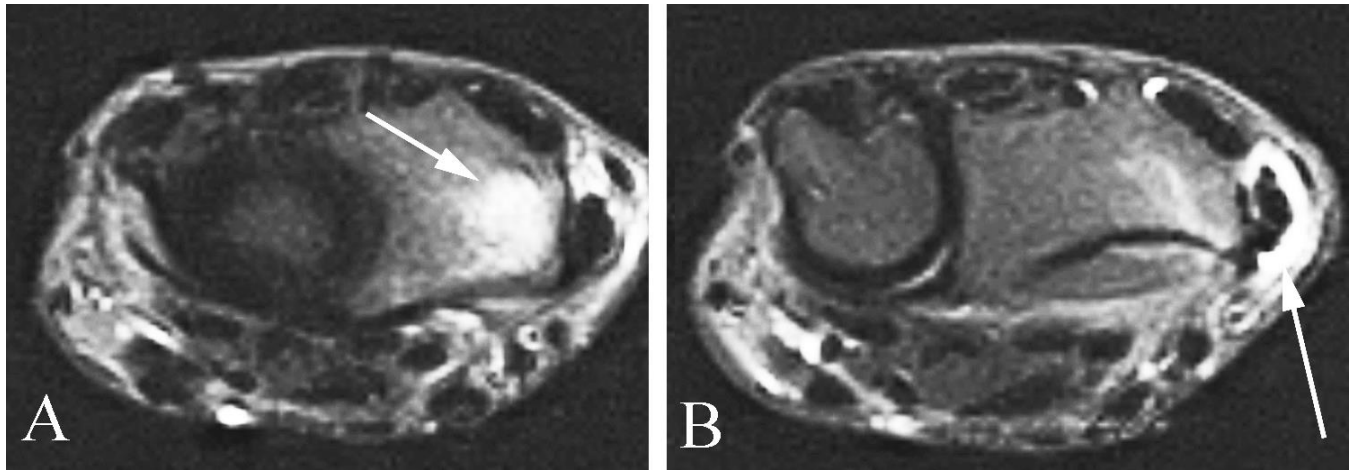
Bone contusion and tenosynovitis of the adductor pollicis longus tendon in a 56 year old woman with direct trauma to the lateral aspect of her wrist. A. Axial fat-suppressed T2 weighted image shows increased signal intensity in the distal, lateral radius (arrow) compatible with bone contusion. B. Axial fat-suppressed T2-weighted image slightly more distal shows fluid surrounding the adductor pollicis longus tendon (arrow) compatible with tenosynovitis.
